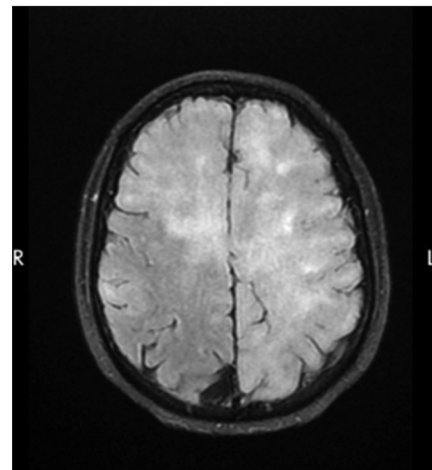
Fluid-attenuated inversion recovery magnetic resonance imaging brain T2 with and without contrast, horizontal section showing diffusely abnormal multifocal areas of irregular thickened signal hyperintensity
